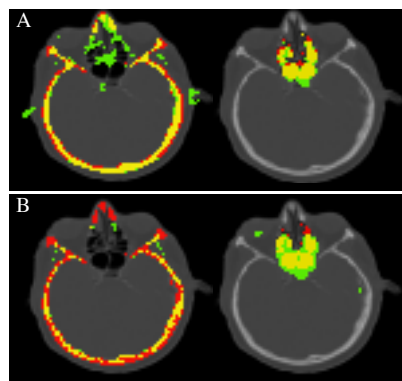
Representative overlap images for bone (left) and air (right) between CT & proposed method (A), CT & vendor method (B) are shown with the true positives (yellow), false positives (green), false negatives (red).
